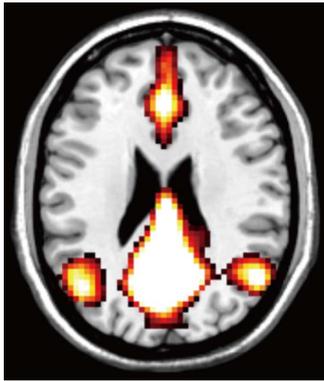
Default mode network, areas active during resting wakeful state. Resting state functional magnetic resonance imaging images using blood oxygenation level dependent technique. Typical areas involved include the medial prefrontal cortices, posterior cingulate, ventral precuneus and parts of parietal lobes (Images kindly prepared by Dr. Michael Stringer).
